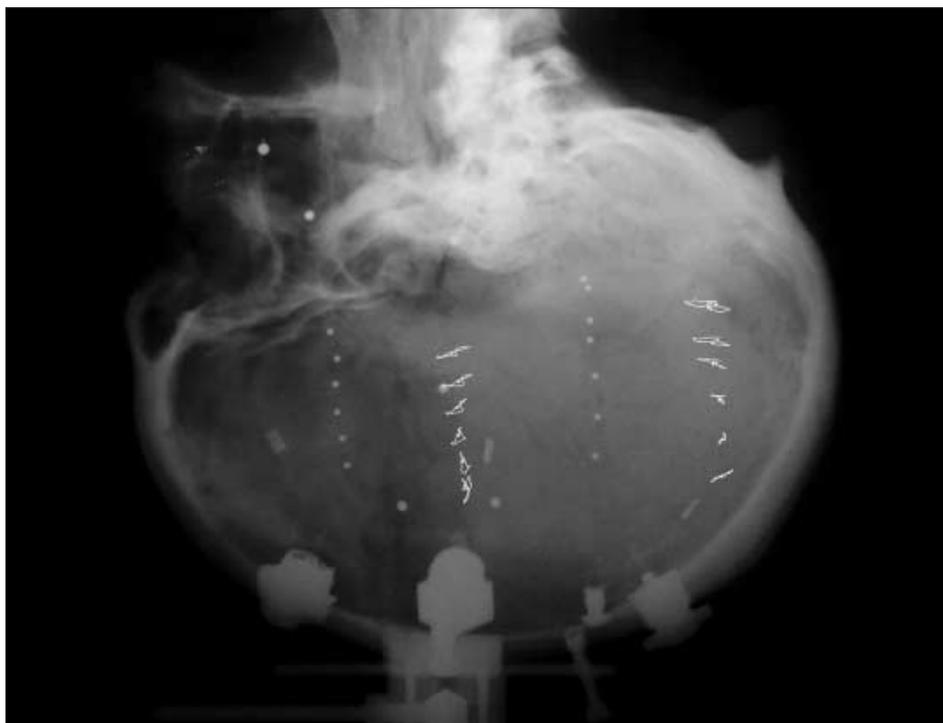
Brain motion shown by biplanar high-speed x-ray.
